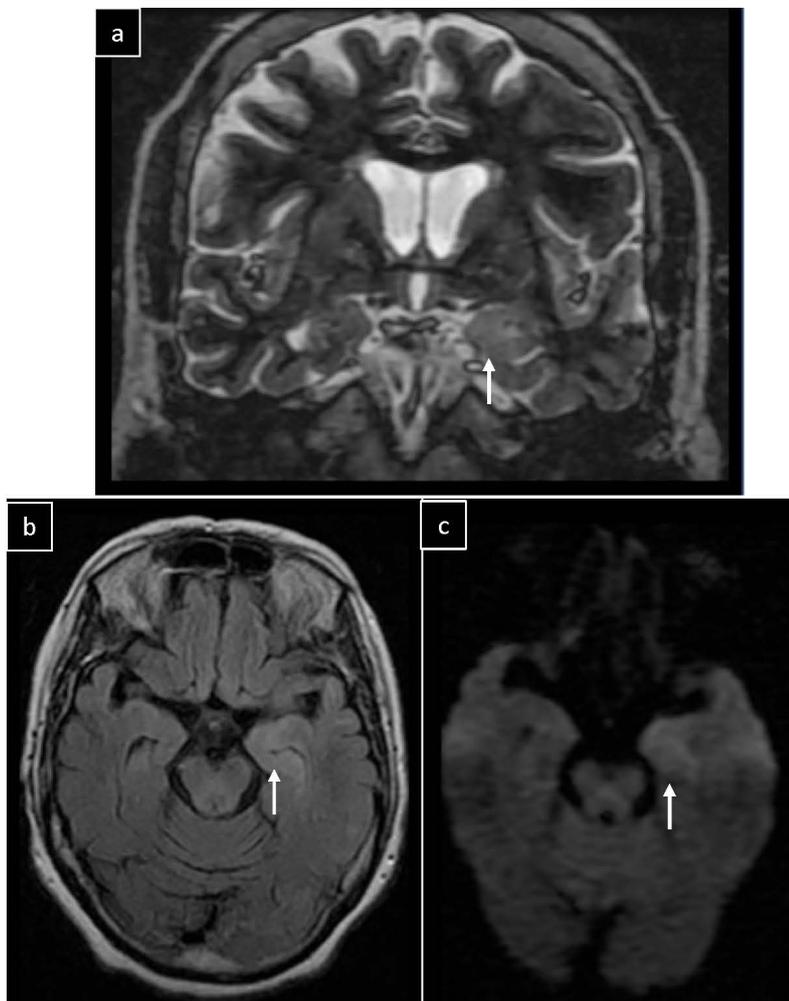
A 70-year-old female presented to the ED with rapid progressing dementia and emotional changes. On axial FLAIR (a, b) bilateral oedema and cortical thickening in the medial temporal lobes (arrows) are noted with no restricted diffusion on DWI (c), suggesting limbic encephalitis. Serological CSF analysis revealed anti-GFAP Abs. A follow-up scan post-treatment showed less prominent imaging lesions on axial contrast-enhanced T1W (d), FLAIR (e) and DWI MR images (f).
